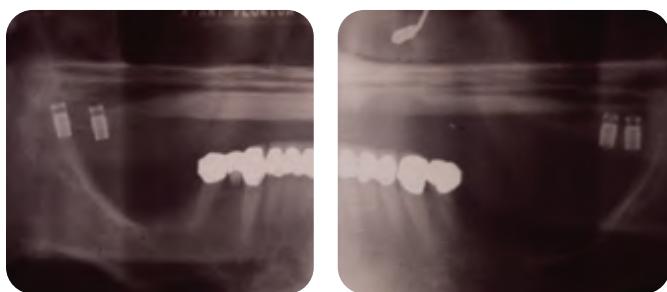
Pretreatment panoramic radiograph. Implants were placed a few years prior but never utilized for a prosthesis. Patient reported that he was unaware of the overall plan. The implants were not integrated and the patient was very discouraged.
